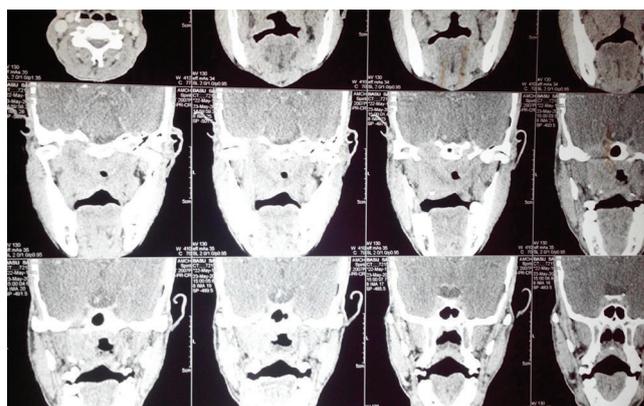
CT scan of head and neck region
